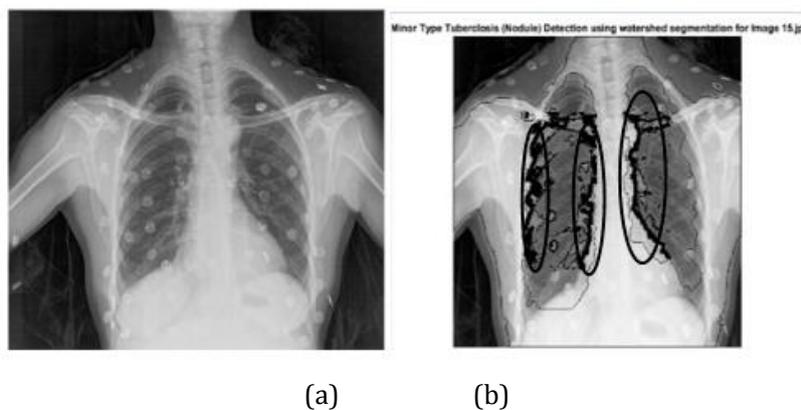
(a) This figure shows original chest radiograph image; (b) This figure shows result for Fig. 2(a).
